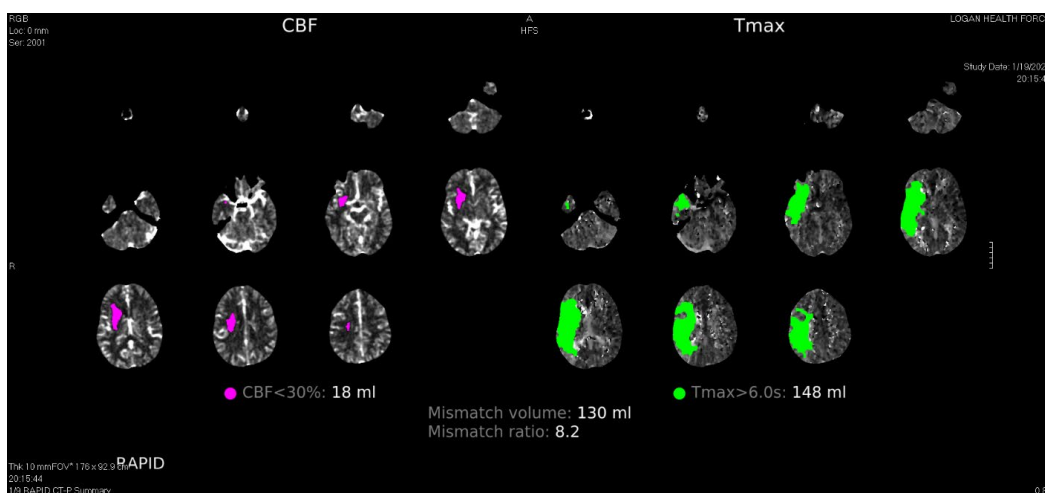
CT perfusion demonstrating small core infarct (red) and large penumbra (green) with a large mismatch volume of 130 ml. This mismatch volume represents viable brain tissue that can still be saved if mechanical thrombectomy is performed and successful.
